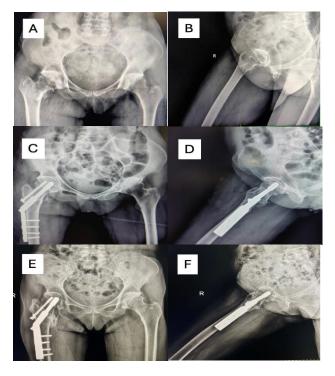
Case 1 (A and B) pre-operative radiographs; (C and D) immediate post-operative radiograph; (E and F) 1-year post-operative follow-up radiograph.
